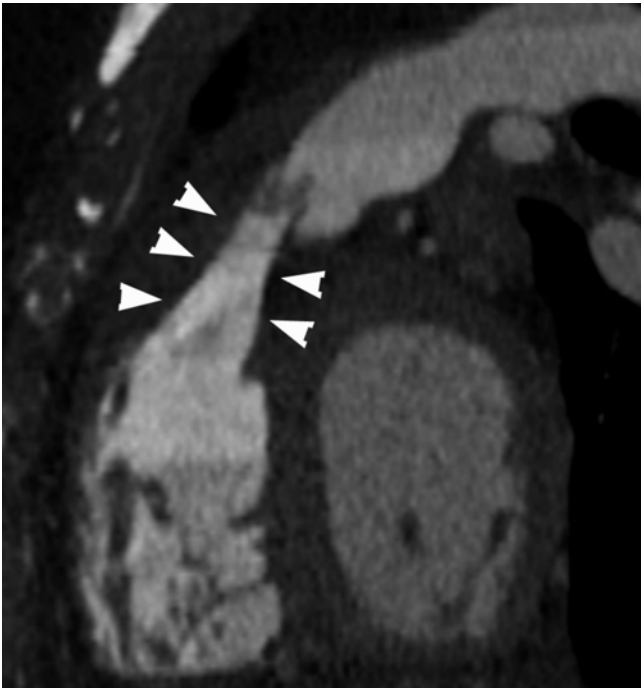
Contrast-enhanced CT in a patient with pulmonary infundibular stenosis (*arrowheads*). The contrast protocol was optimized to provide adequate opacification of right heart chambers
